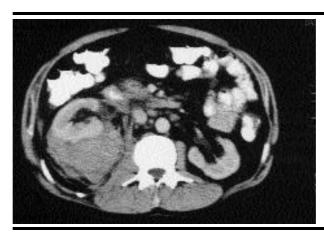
Abdominal computed tomography revealing a right perirenal and retroperitoneal haematoma.
